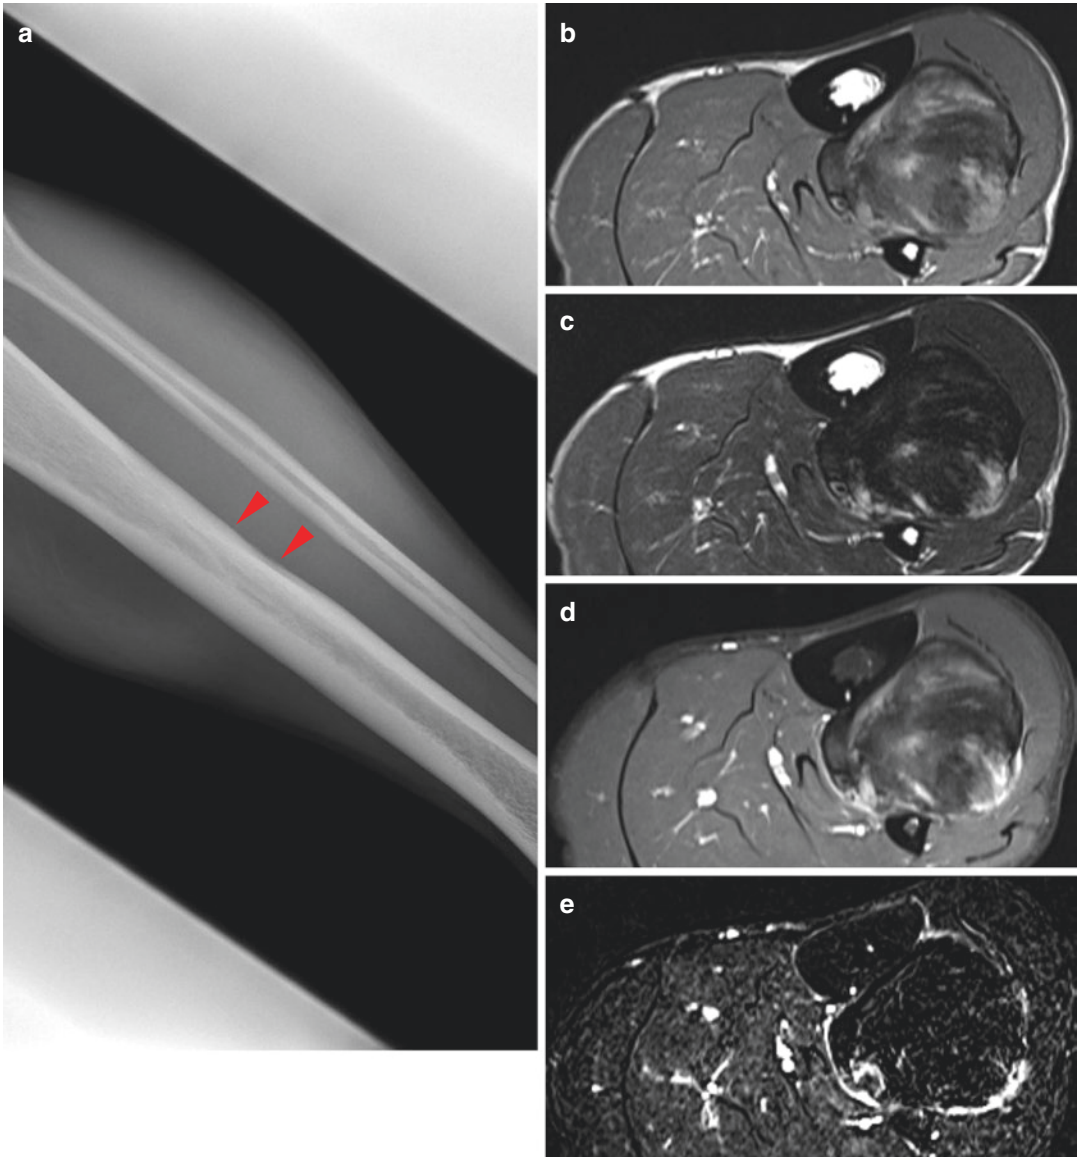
Pleomorphic rhabdomyosarcoma. Radiograph (a) shows shallow cortical scalloping (*arrowheads*) of the tibial shaft. Axial T1WI (b) reveals a circumscribed mass between the tibia and fibula, with a mixed signal that ranges from dark to hyperintense. The lesion has dark signal on T2WI (c) and has hyperintense foci. Postcontrast
